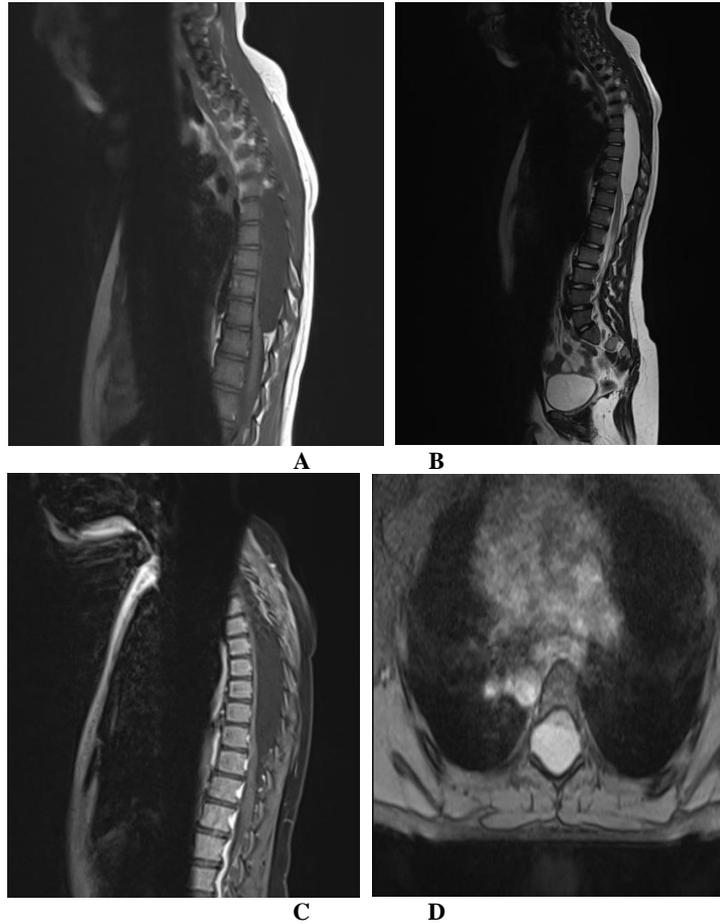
Spinal cord MRI in sagittal T1 (a), T2 (b), FATSAT (c) and axial T2 (d) slices showing a thoracic cystic formation, signal identical to that of the CSF, hypointense in T1, hyperintense in T2, unenhanced after injection of PDC, posteriorly localised and pressing the cord against the posterior wall of the vertebral bodies
